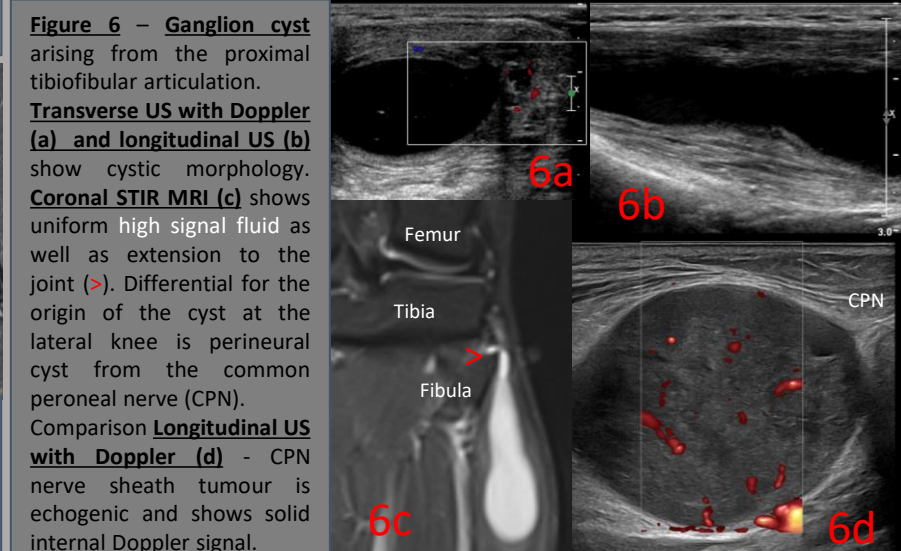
Ganglion cyst arising from the proximal tibiofibular articulation. Transverse US with Doppler (a) and longitudinal US (b) show cystic morphology. Coronal STIR MRI (c) shows uniform high signal fluid as well as extension to the joint (>). Differential for the origin of the cyst at the lateral knee is perineural cyst from the common peroneal nerve (CPN). Comparison Longitudinal US with Doppler (d) - CPN nerve sheath tumour is echogenic and shows solid internal Doppler signal.
